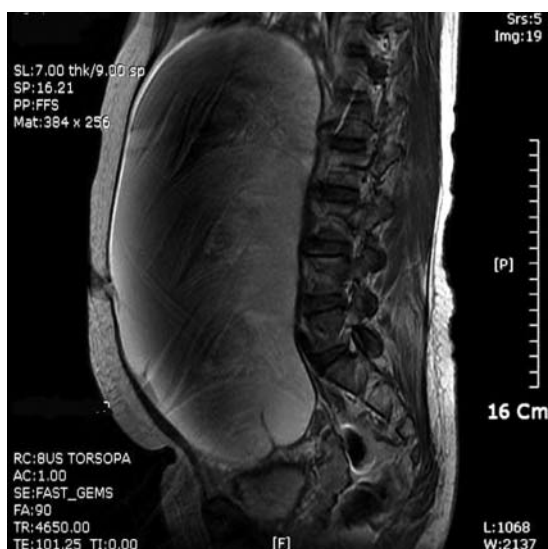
Magnetic resonance imaging of large ovary cyst measuring 26 cm (T2-sagittal).
